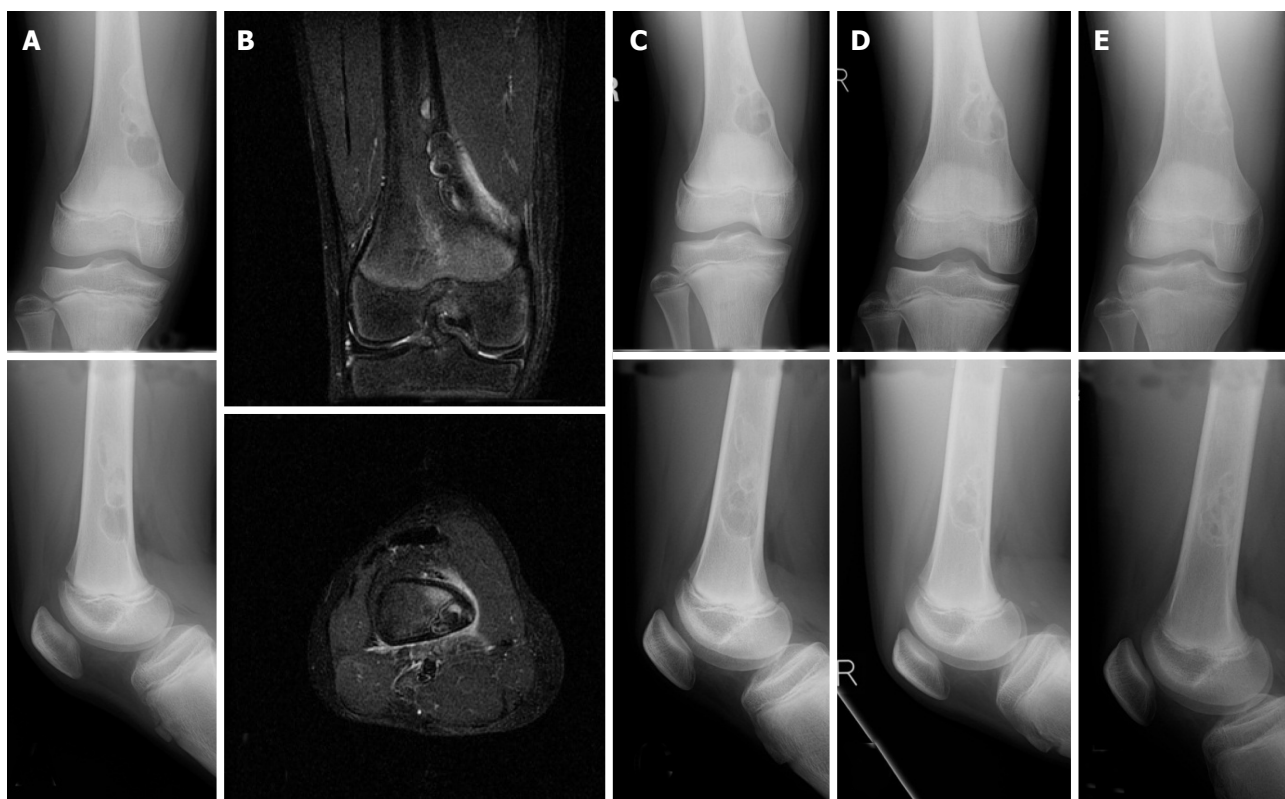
Plain radiograph and MRI of a NOF in the femur of a 13-year-old male who sustained a fracture. The plain radiographs reveal a multinodular lesion located at the medial posterior part of the distal femur. The lesion is osteolytic at the distal end and ossified at the proximal end. The lesion has expanded at the medial cortex (A). T2-weighted fat-suppression MRIs show high signal intensity and suggest the presence of a fracture (B) (coronal, top; axial, bottom). Radiographs taken after 1 year (C), 1 year and 8 mo (D), and 2 years and 8 mo (E); these radiographs reveal the lesion had enlarged as well as ossified (plain radiographs: anteroposterior view, top; lateral view, bottom).
